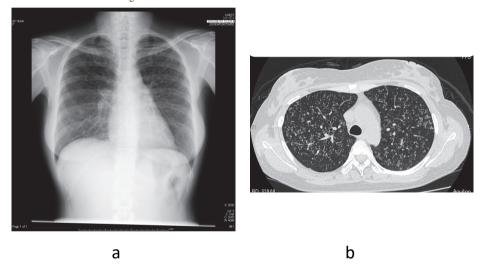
A 43-year-old woman showed diffuse small nodular shadows in the bilateral lung field on a chest radiograph (a) and diffuse small nodular shadows in the bilateral lung on chest CT (b). (Diagnosis: Miliary tuberculosis)
